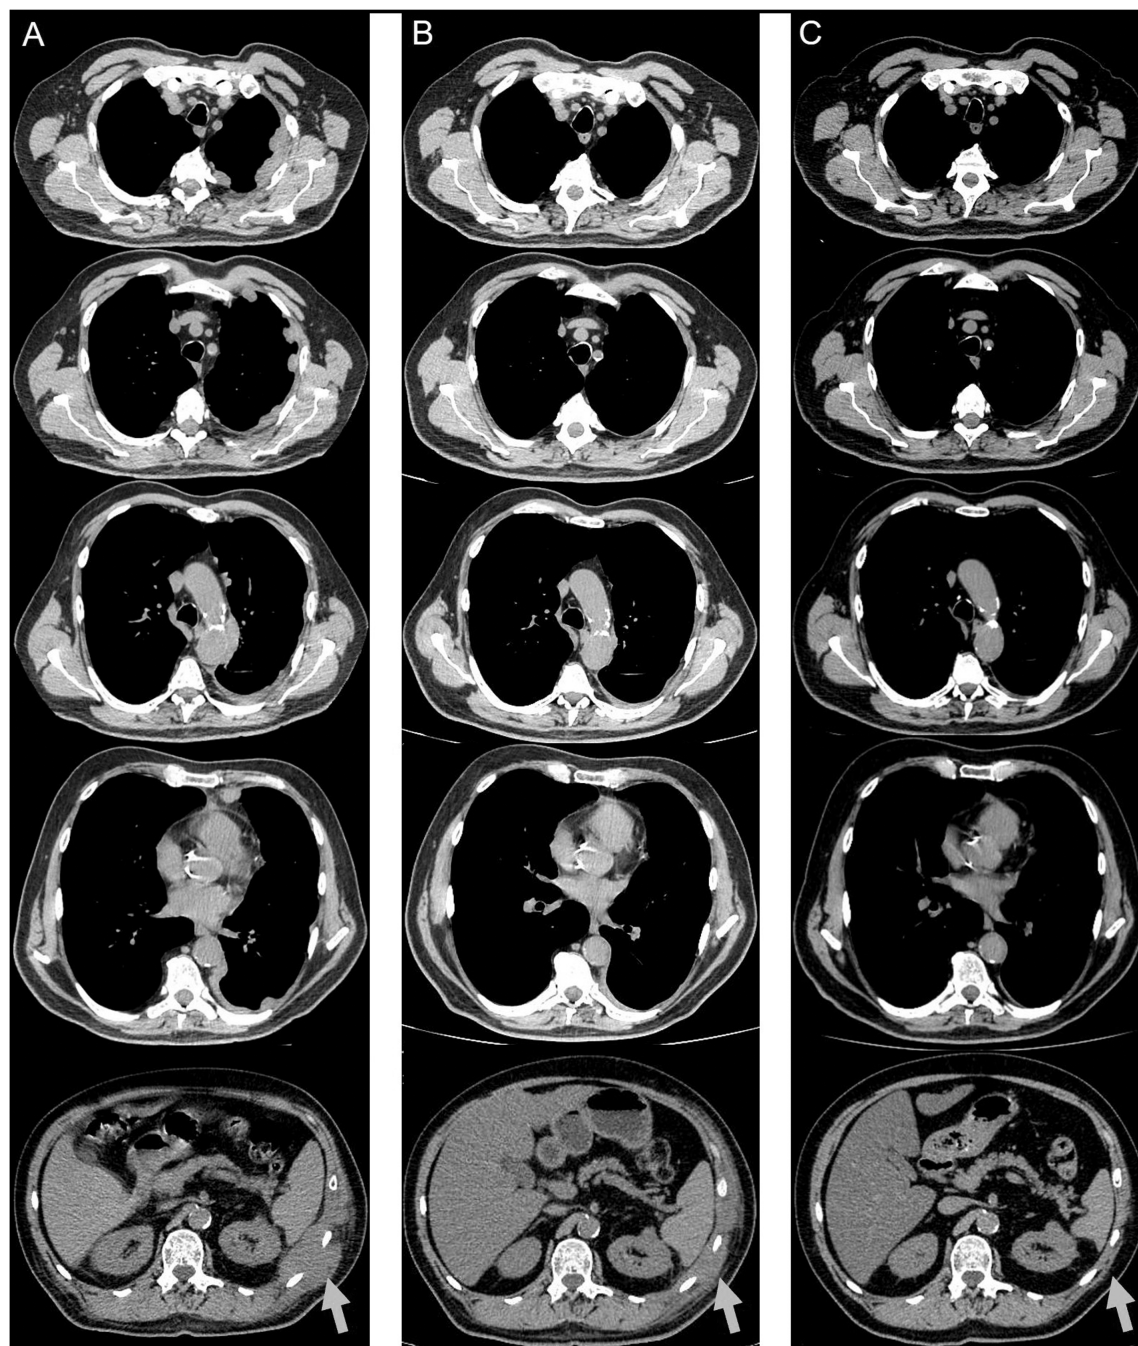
Serial reassessments by computed tomography scan documenting the lesions' extension and evolution. (A) After 6 treatment cycles of carboplatin-pemetrexed chemotherapy, reflecting recurrence of disease in the left hemithorax. (B) After 4 treatment cycles of nivolumab, demonstrating partial but impressive response. (C) After 37 treatment cycles of nivolumab with no evidence of recurrence and maintaining remarkable tumour response.
